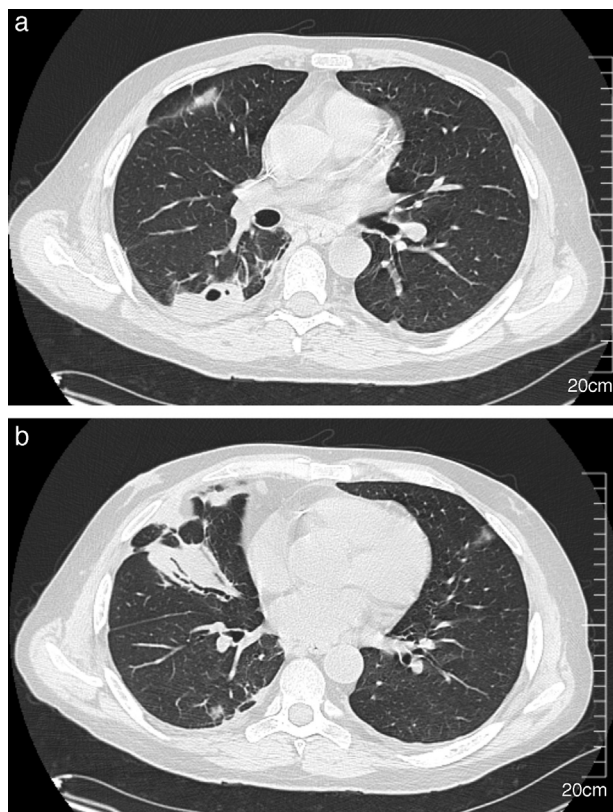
Chest CT scan showing right-sided multiple pulmonary nodules with cavitation (A) and parenchymal consolidation in the middle lobe (B).
